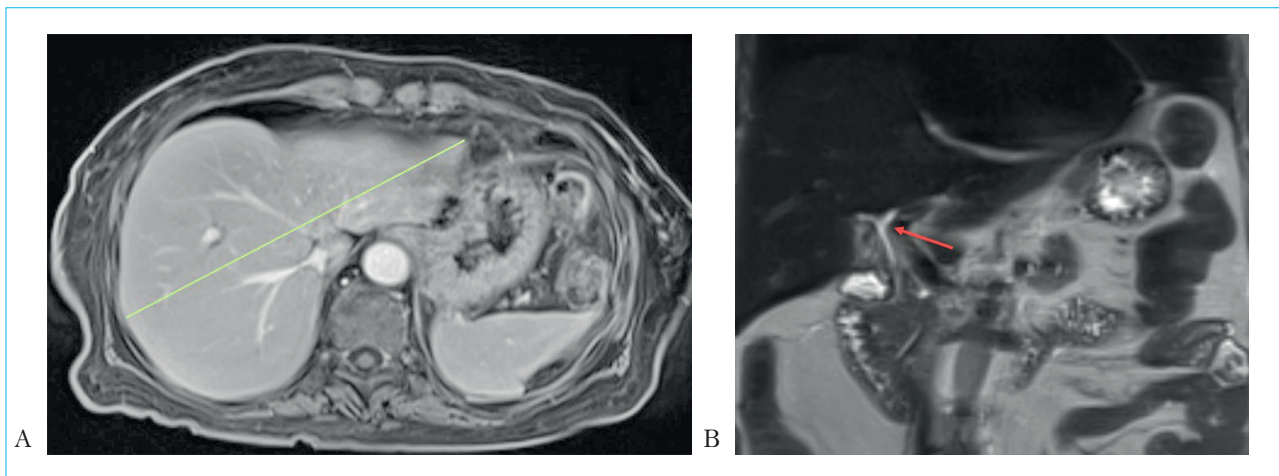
Contrast enhanced MRI of the abdomen: The liver (oblique size up to 14 cm) and spleen are not enlarged. No excretion of contrast agent into the bile ducts and gallbladder lumen was obtained in the hepatospecific phase 18 min after the contrast agent injection (A). MRCP. Common bile duct is up to 5 mm, contrasts evenly. Intra- and extrahepatic bile ducts are not dilated (red arrow: common bile duct and lobe ducts) (B)
